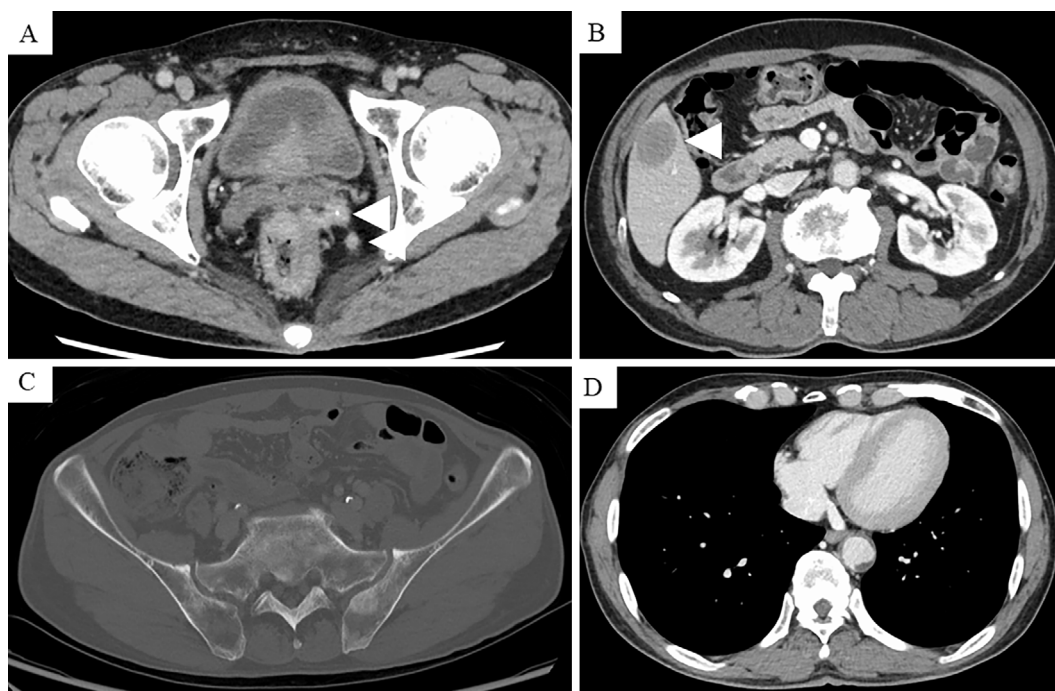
CT findings at the initial diagnosis of NET. Computed tomography at the initial diagnosis showed swelling of multiple lymph nodes (A: arrowheads) without the detection of the primary lesion and liver metastasis (B: arrowhead), consolidation of the vertebra and iliac bone (C), and findings of a tumor and an abnormal enhancement in the left ventricle and septum (D).
